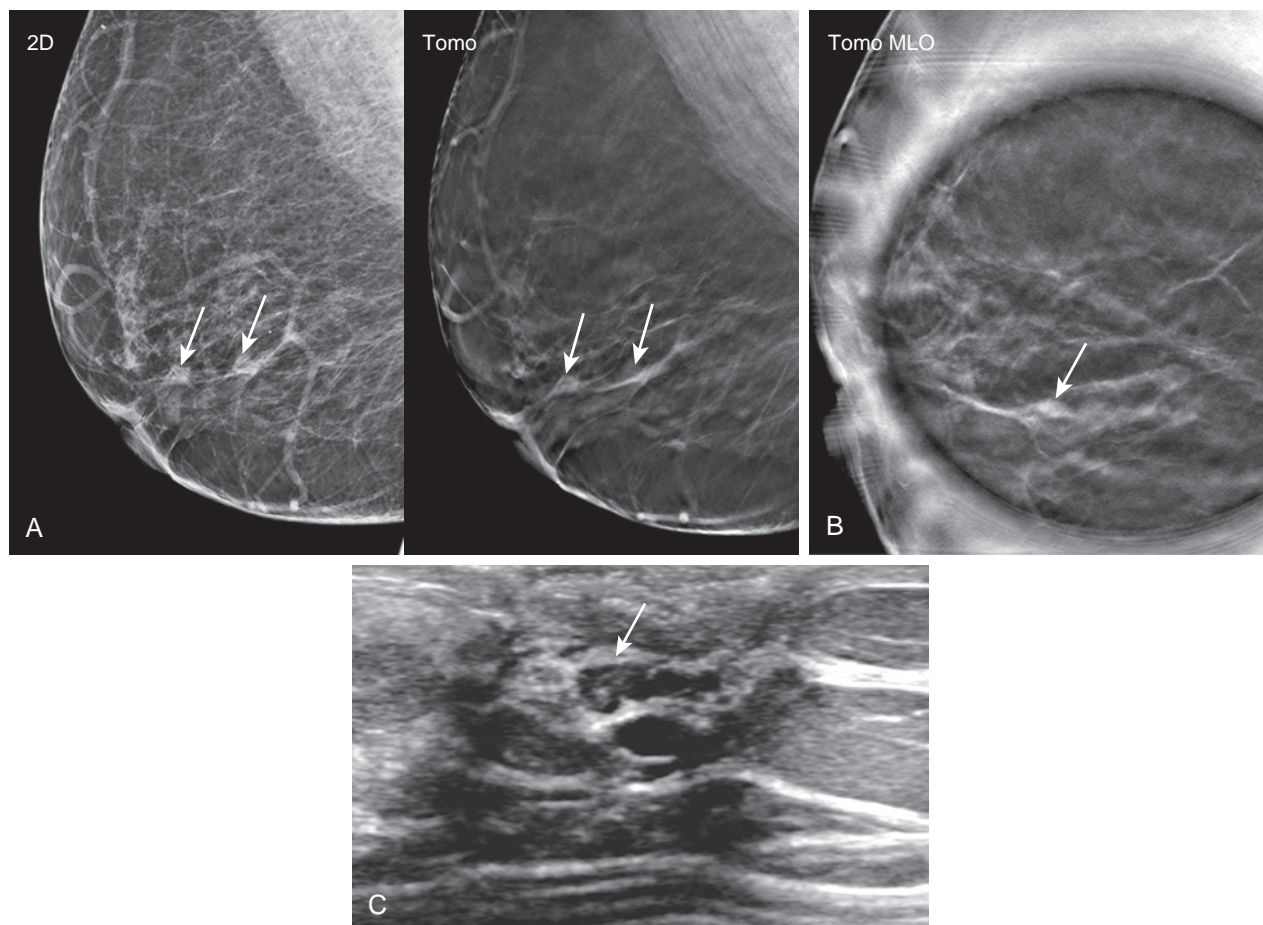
Intraductal papillomas well seen on 2D mammography (A) Screening mammogram in a 58-year-old woman with two new asymmetries (*arrows*) in the right retroareolar breast, seen only on the mediolateral oblique view. The more posterior asymmetry did not persist on tomosynthesis. (B) Spot compression tomosynthesis view again demonstrates only the anterior asymmetry (*arrow*) and does not add any additional information. (C) Targeted ultrasound reveals a corresponding intraductal mass (*arrow*). Ultrasound-guided core needle biopsy revealed benign papilloma, confirmed with surgical excision.
